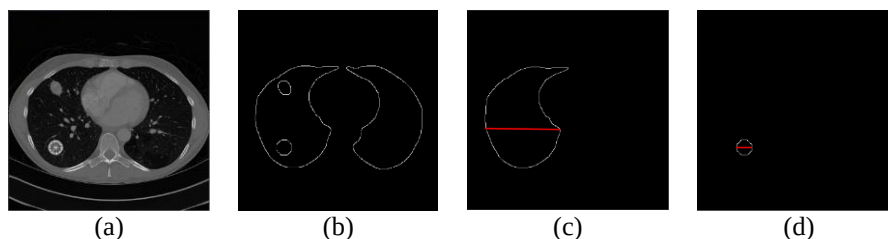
PNMR quantities: (a) CT image with synthetic nodule, (b) cannty edge detected image, (c) lung parenchyma measurement, and (d) nodule measuereement
